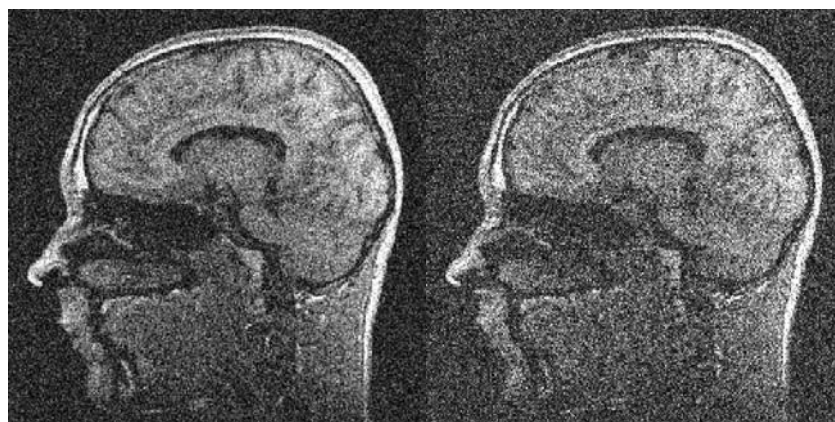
Image noise is present in practically all MR images and is one of the effects of the major limiting factors for MRI protocols.
